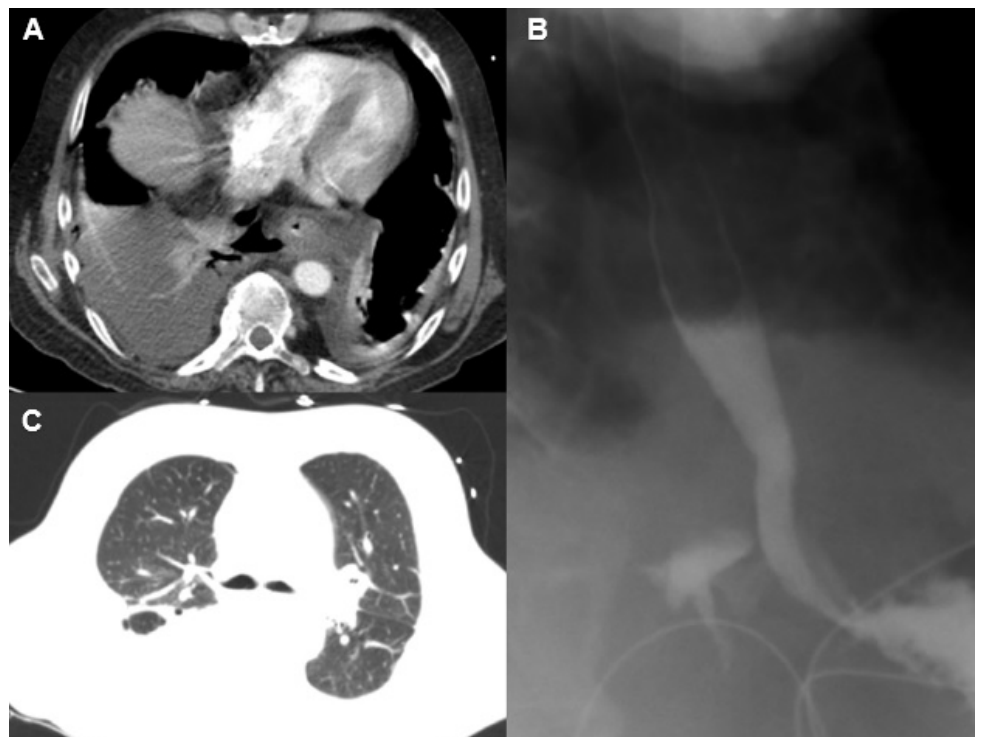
A-ESOPHAGRAM UPON PRESENTATION, REVEALING LEAK OF CONTRAST MATERIAL INTO RIGHT POSTERIOR CHEST; B-INITIAL CT SCAN SHOWING BILATERAL EFFUSIONS; C-INITIAL CT SCAN SHOWING LACK OF CLASSIC RADIOLOGICAL FINDINGS OF COVID-19.
